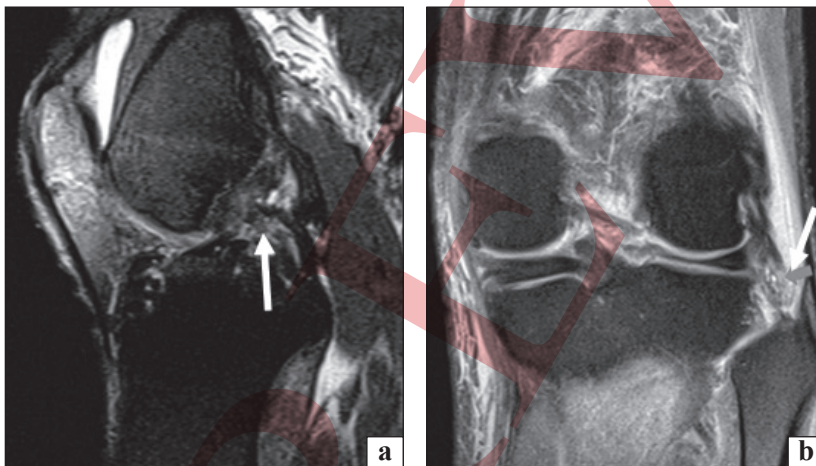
Sagittal and coronal MRI scans of an angular injury in the left knee: a) rupture of the PCL (arrow) visible in the sagittal projection; b) high signal on the lateral collateral ligament (arrow) visible in the coronal projection
